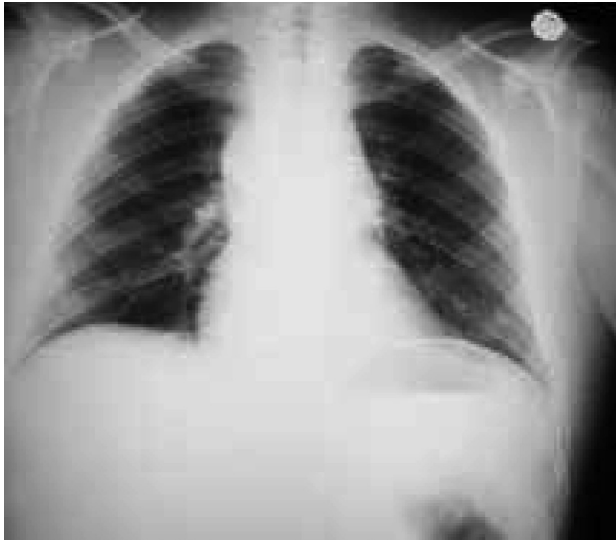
Chest x-ray showing the increased mediastinum
